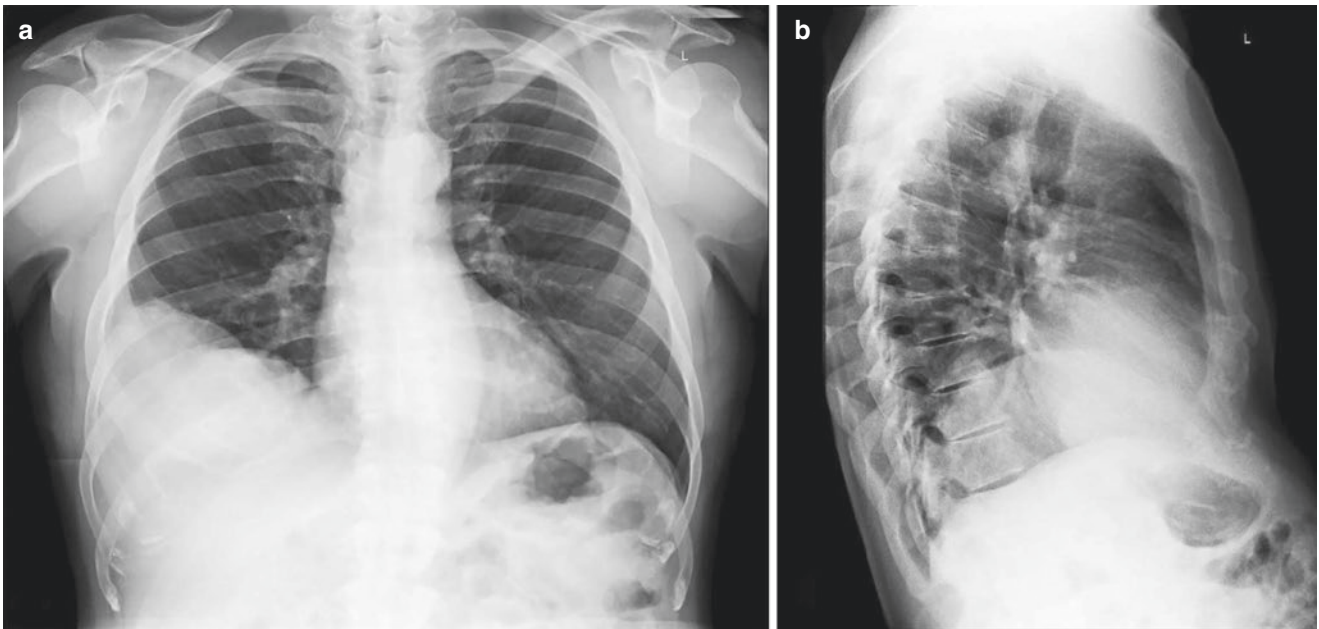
Chest X-ray (a) anteroposterior view; (b) lateral view showing a large right lower lung mass. Reprinted from Qorbani A, Nelson SD. Primary pulmonary undifferentiated pleomorphic sarcoma
